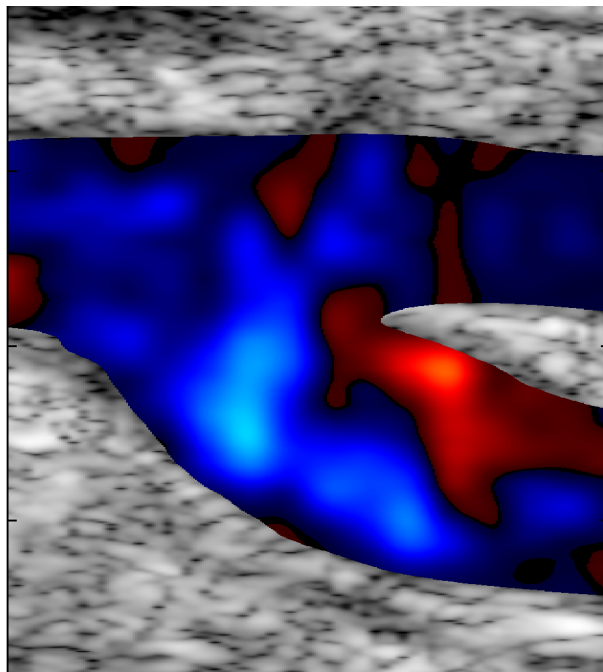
Ultrasound scanning with conventional color flow mapping of the carotid bifurcation. The complex flow in the carotid bulb (bottom right) is visible, however, not quantified.*
